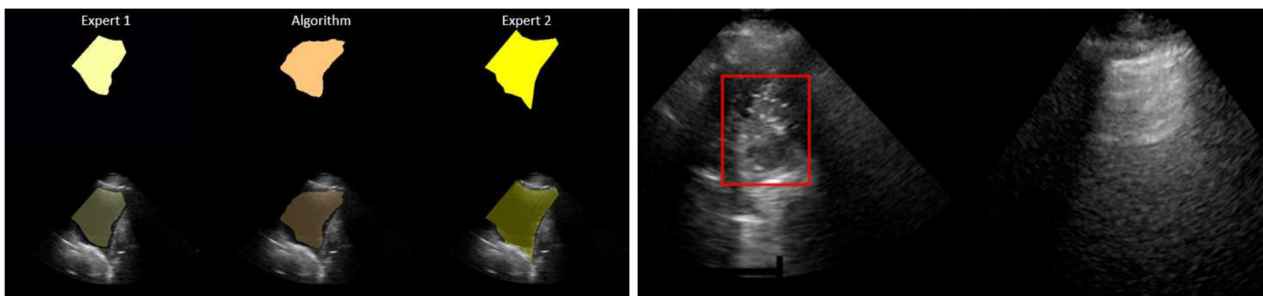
On the left, an example of a lung ultrasound image and corresponding segmentations generated by expert 1, expert 2 and the algorithm respectively. On the right, automatic identification of the consolidations in an unhealthy patient with bounding box (red, left), compared to a healthy patient (right).
